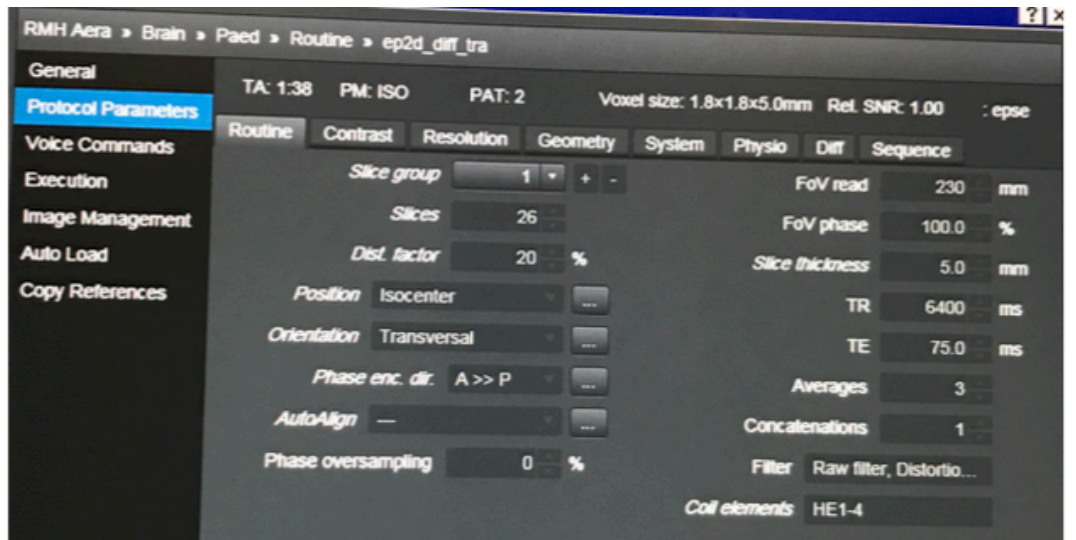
a: Protocol parameters of the DW-MRI of the head.
